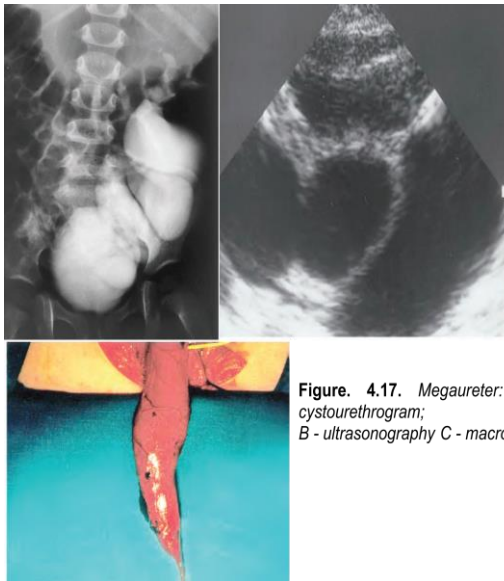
Megaureter: A - ascending cystourethrogram; B - ultrasonography C - macro preparations
